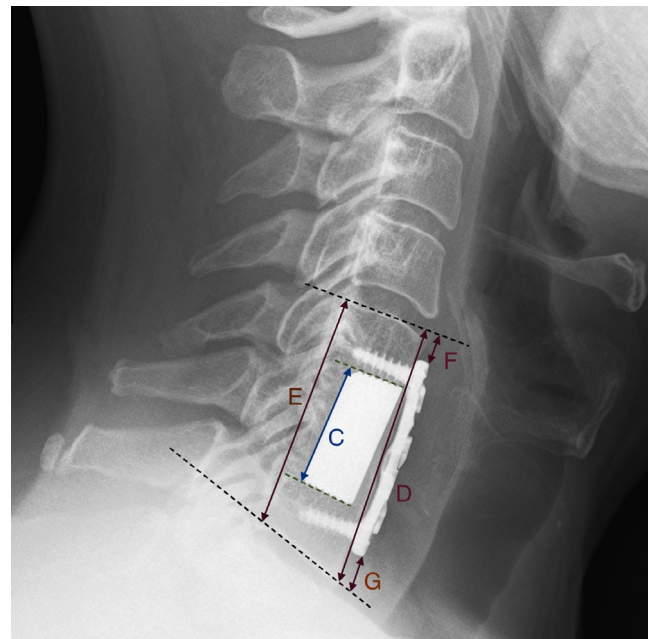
Lateral X-ray showing fused segment. (C) Known height of implant used as calibration, (D) anterior height of fused segment, (E) posterior height of fused segment, (F) cranial disc-plate height, (G) caudal disc-plate height.
